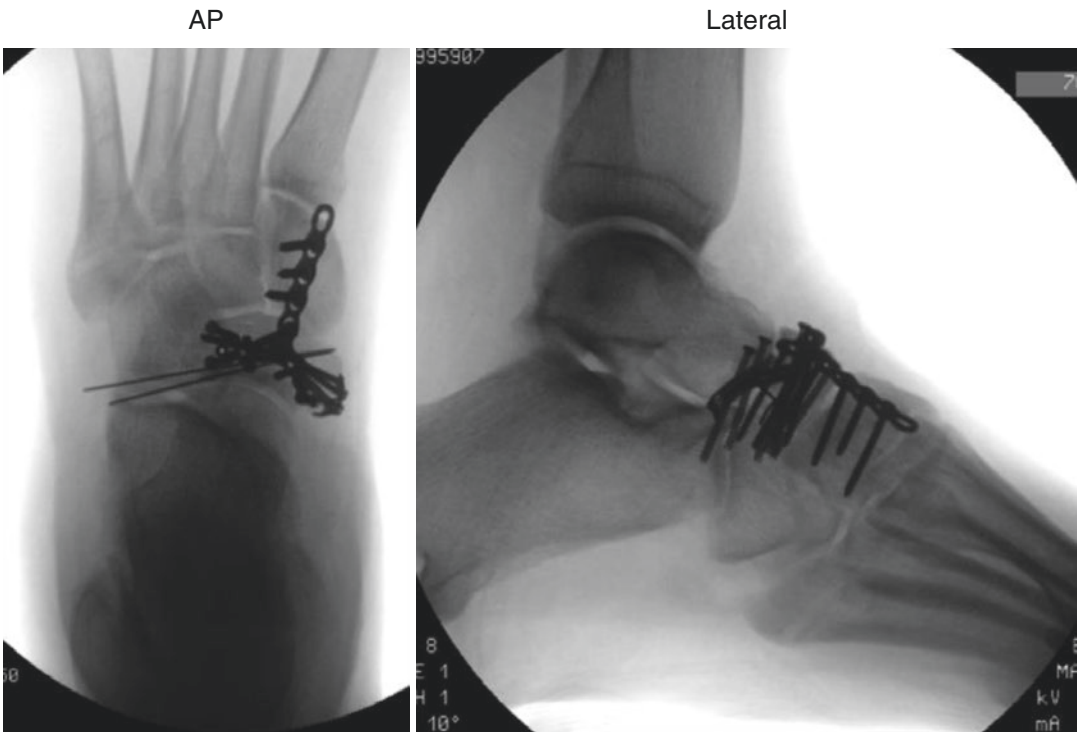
Radiographs of definitive fixation construct. K-wires and independent screws maintain the navicular fracture reduction, and a 2.4 T-plate was used to stabilize the navicular to the medial cuneiform
